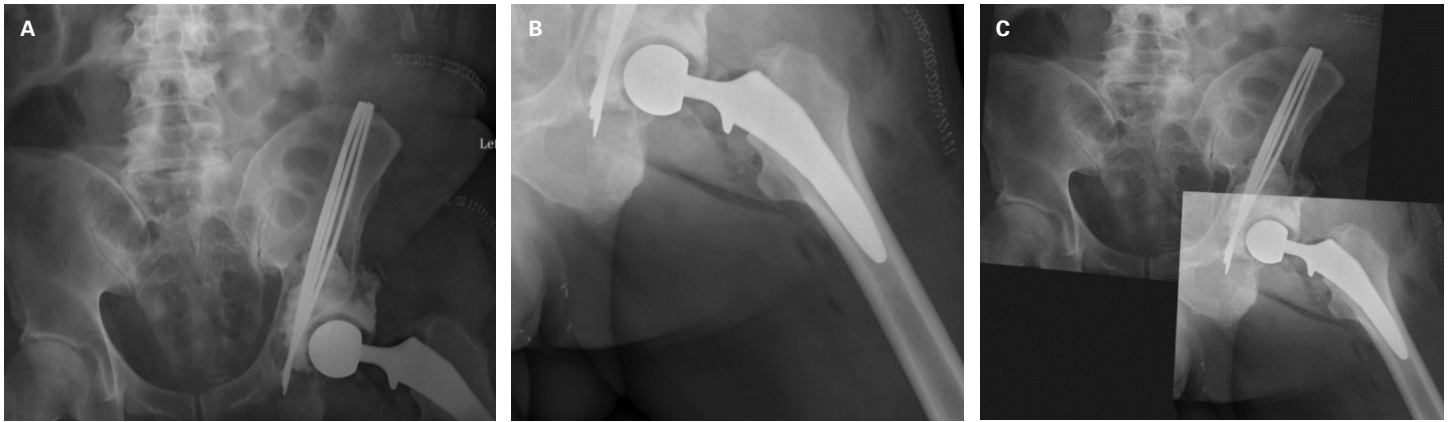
Post-operative X-ray status post left hip Harrington with total hip arthroplasty.
